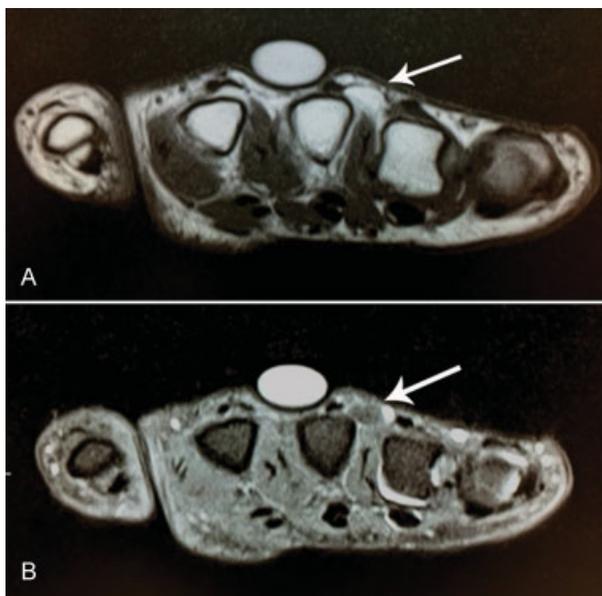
(A) Axial T1-weighted and (B) coronal fat-suppressed T2-weighted images reveal a subcutaneous lipoma on the hand's dorsal side (arrows).
